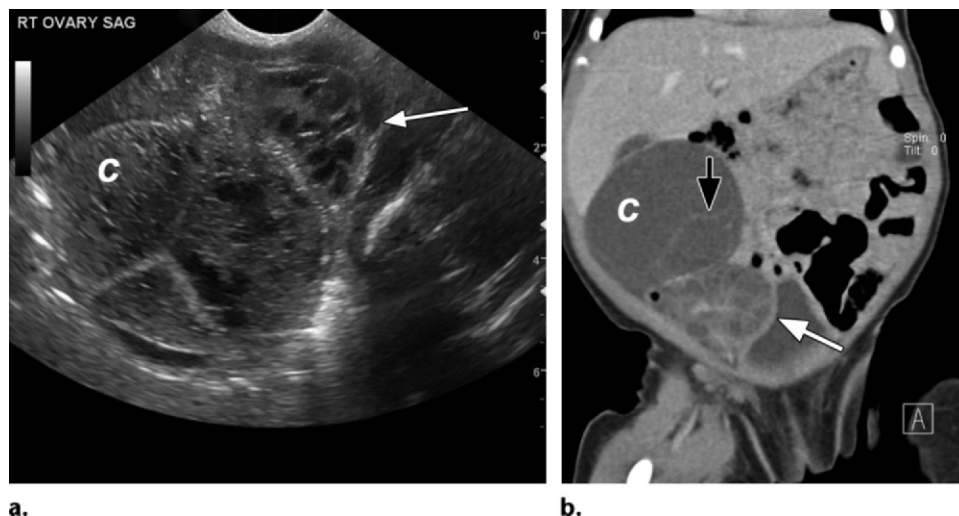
Neonatal ovarian torsion in a 2-day-old infant with a prenatally diagnosed mass. The mass was surgically confirmed to be due to left ovarian torsion with a prenatally diagnosed mass. The mass was surgically confirmed to be due to left ovarian torsion with a prenatally diagnosed mass. The mass was surgically confirmed to be due to left ovarian torsion with a prenatally diagnosed mass. (a) Sagittal US image shows a complex cyst (C) with thick meshlike septa and multiple echogenic reticulations, consistent with evolving hemorrhage. The left ovary (arrow) with multiple dilated follicles is seen in the right pelvis. (b) Coronal CT image shows a large complex cyst (C) with a thin septum (black arrow). Inferiorly and to the left, a cystic-appearing left ovary (white arrow) contains multiple enlarged follicles. The patient underwent cystectomy and detorsion.
